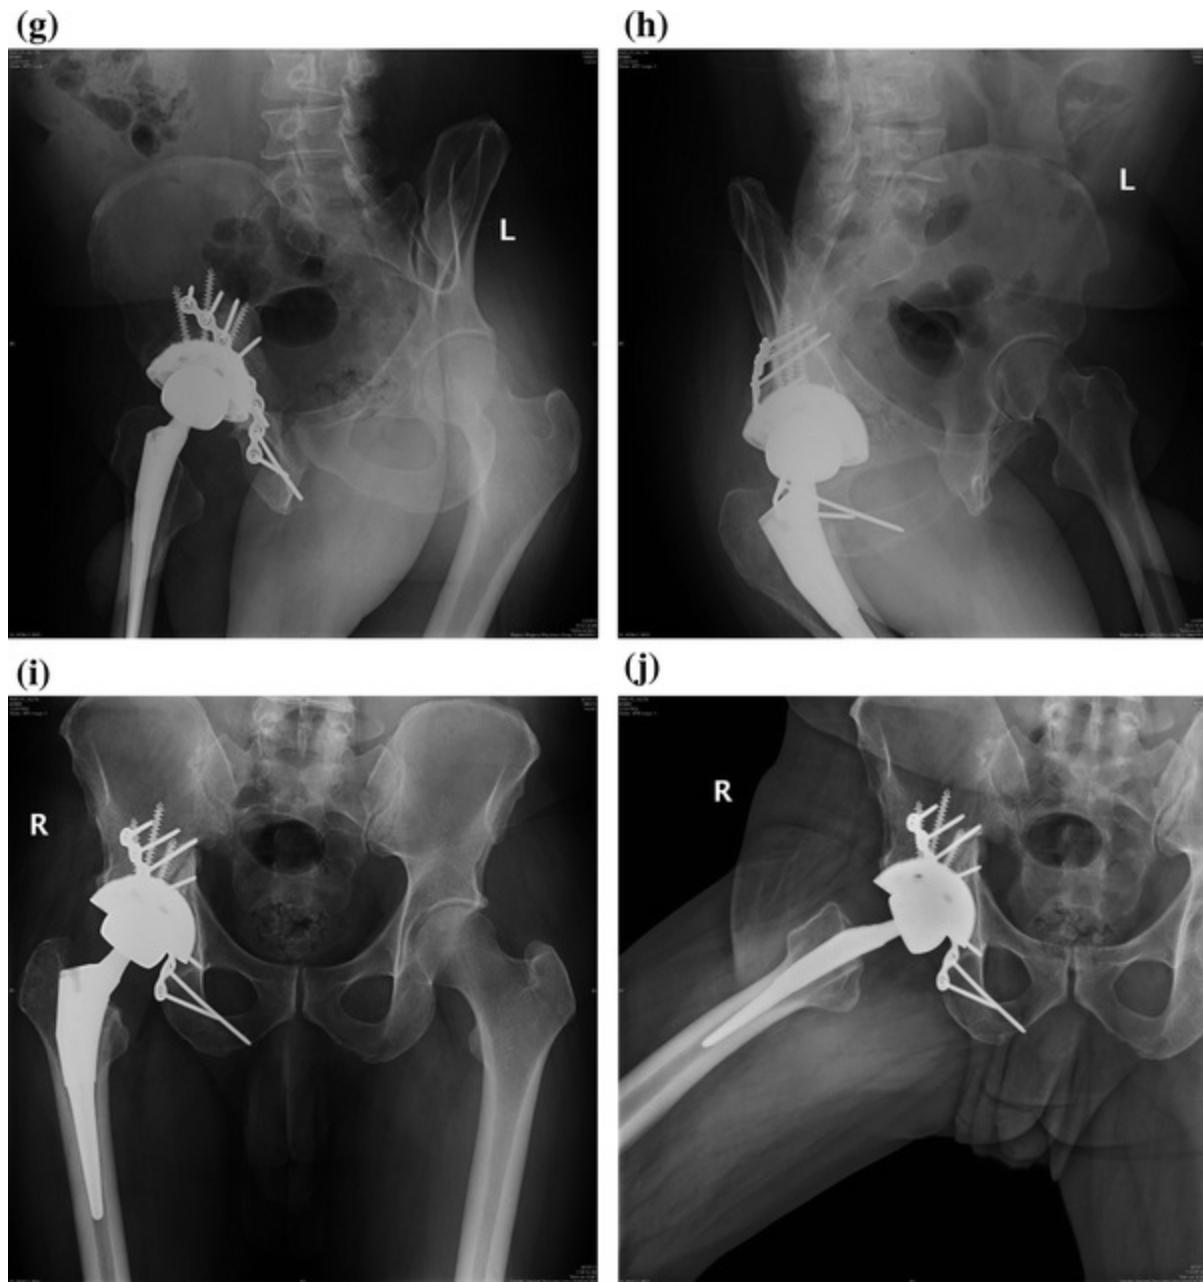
a, b Anteroposterior (AP) of the pelvis at the time of the accident 5 years before presentation pre- and postreduction of the hip dislocation. c AP pelvis at presentation with a complete nonunion and end-stage osteoarthritis. d, e Axial CT showing a complete nonunion of the transverse fracture without any of the cuts showing bridging and the end-stage osteoarthritis. f AP pelvis postsingle-stage open reduction internal fixation and hip arthroplasty through a Kocher-Langenbeck approach. g–j Six-month follow-up with both 45° oblique views, and AP and lateral of *right hip* showing solid fixation and patient without pain
